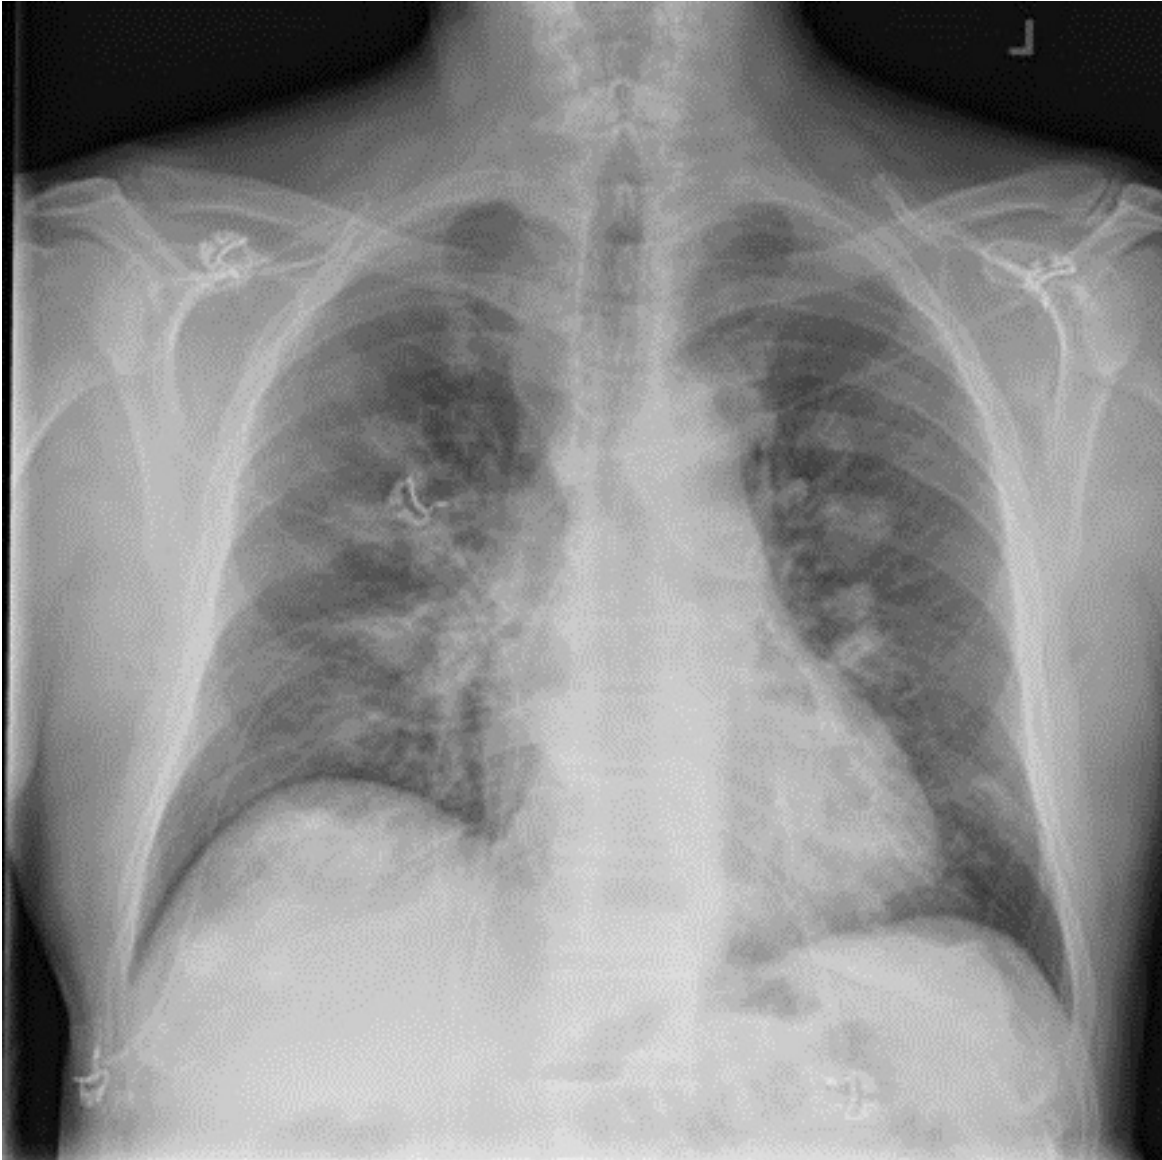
Initial PA radiograph of chest.
